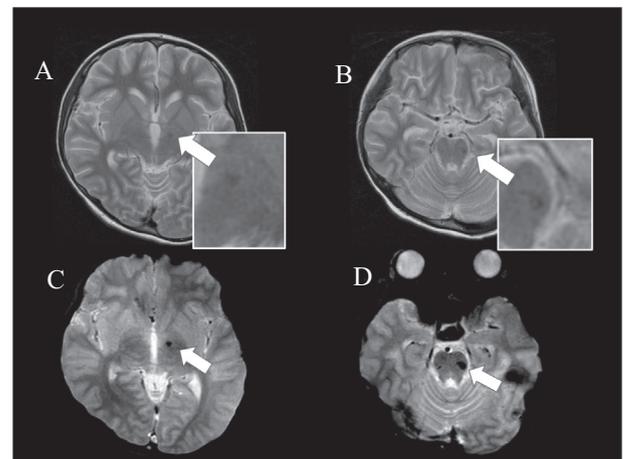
MRI at 2 months and 2 years after disease onset in case 1. (A, B) T2-weighted MRI imaging (T2WI) at 2 months after onset. (C, D) T2*WI at 2 years after onset. T2WI at 2 months after onset revealed dilated ventricles and sulci, and low intensity lesions (arrow) in the left thalamus (A) and left pons (B). T2*WI at 2 years from onset revealed that these lesions were chronic hemorrhages (C, D, arrow).
